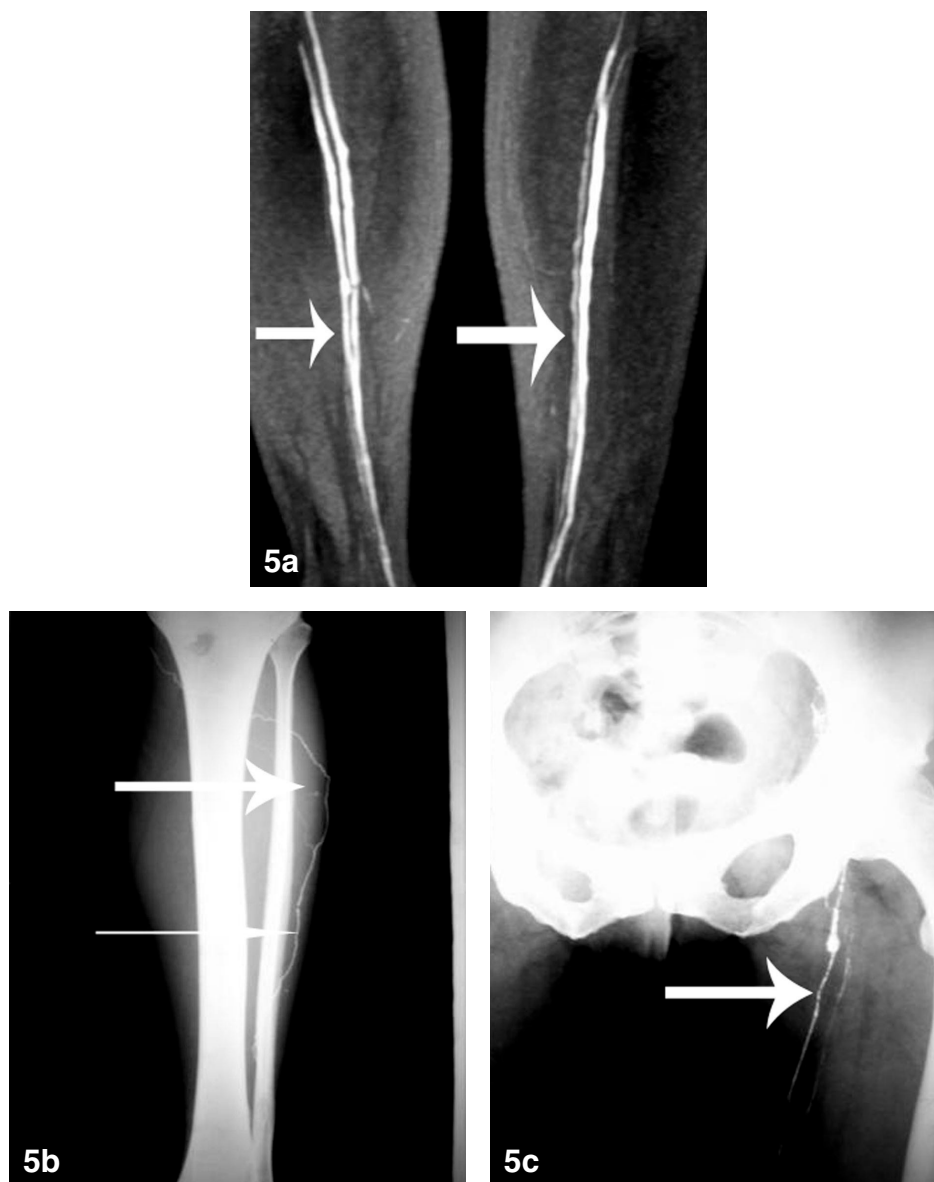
Depiction only of veins (a, white arrows) in IMPRL which was confirmed by direct x-ray lymphography (b,c) in a subject with lymphedema (No 7. from Table 1).
